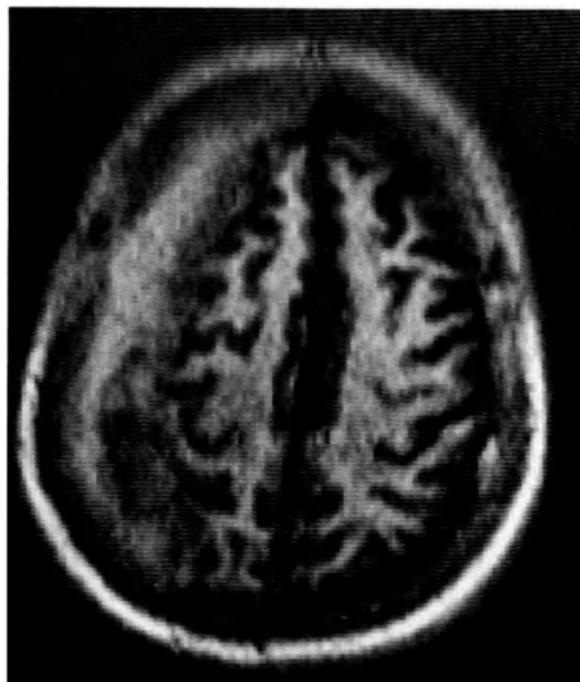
MRI study ( $T_1$ -weighted) shows right subdural as high signal.
